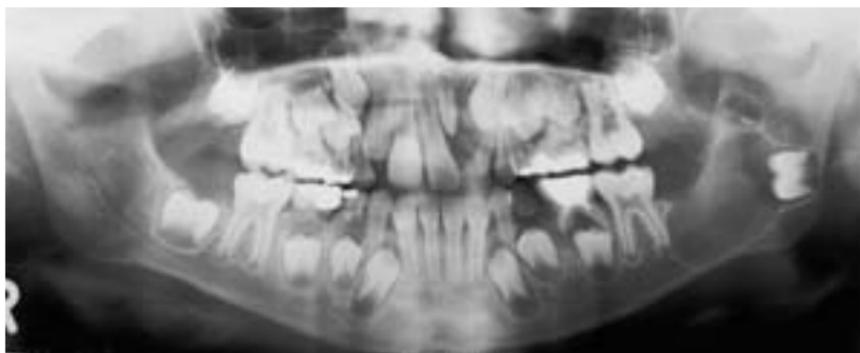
Ameloblastic fibroma. The panoramic radiograph of an 8-year-old male reveals an early stage ameloblastic fibroma. In contrast to a follicular cyst, the well-demarcated radiolucency sits like a hat on the occlusal surface of the displaced third molar (47) and is not attached at the cementoenamel junction of that tooth. The pericoronal follicular sac appears in this radiograph to have not communicated with the oral cavity.
